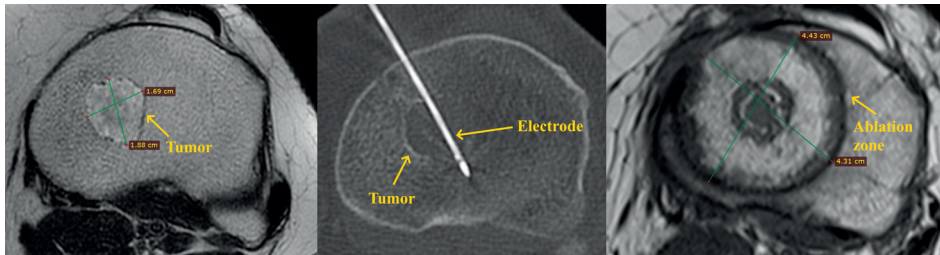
Pre-, intra-, and post-operative images of the representative clinical case used for the analysis. The tumor is poorly visible on the CT images given its low density, but it is easy to see on the MR images. Figure 1A shows the preoperative MR image of a cartilage tumor in a tibia metaphysis, where the tumor is visible within the trabecular bone. Figure 1B, intra-operative CT images of the same cartilage tumor, the RF electrode is seen entering from top left of the image. Figure 1C shows the post-procedural MR image with the resulting ablation zone after the RFA intervention. Here, the hypointense focus represents the ablated tumor, and the hypointense contours surrounding it represent the borders of the ablation zone. The corresponding resulting ablation diameters are indicated with caliper measurements.
